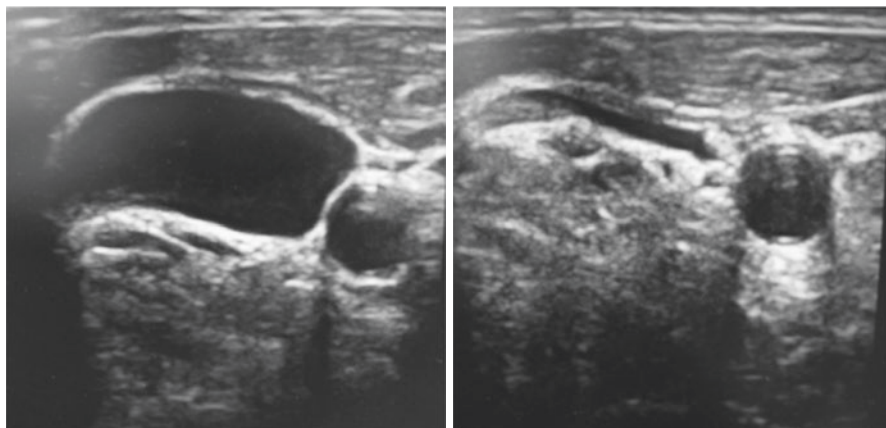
Ultrasound image. Compressible internal jugular vein
